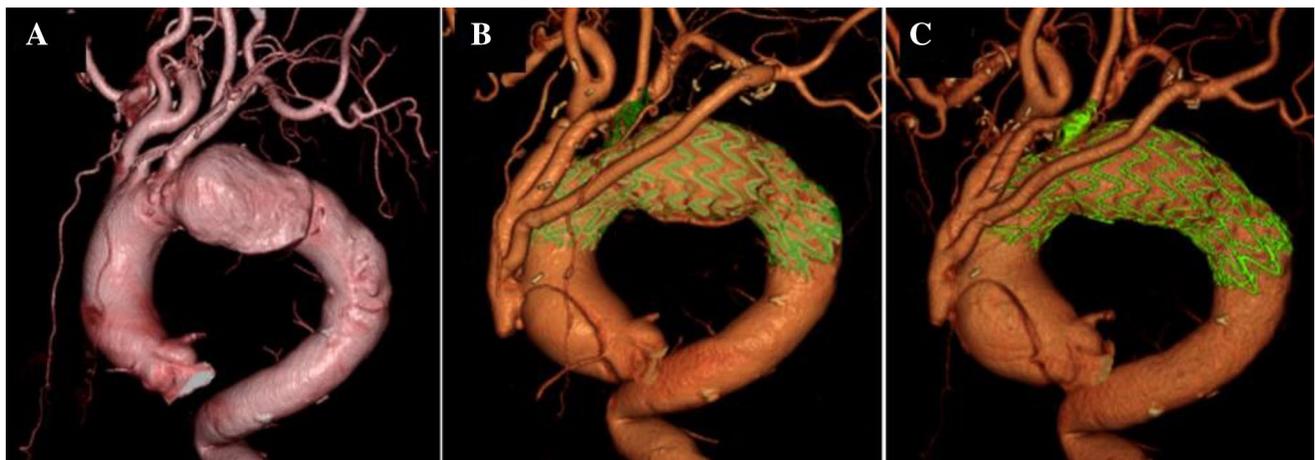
Three-dimensional computed tomography findings for Case 2 showing a the distal arch aneurysm before the initial procedure. b A new type A aortic dissection with ascending aorta diameter 50 mm
